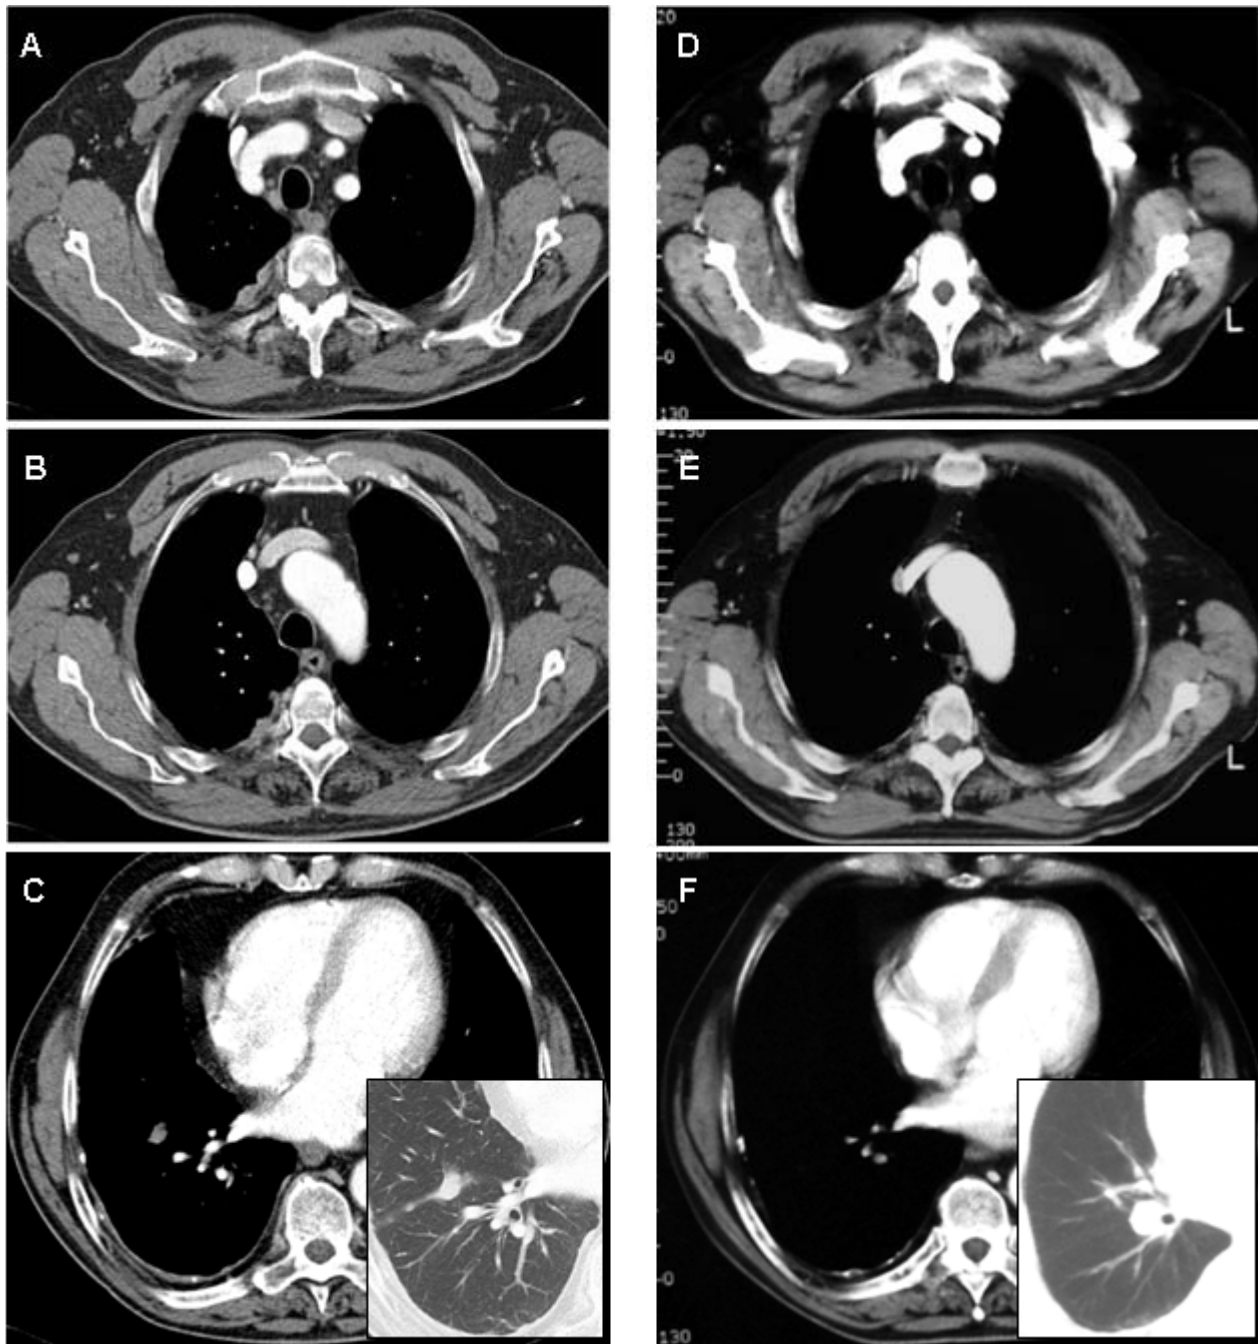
Mediastinal windows of CT-scan before chemotherapy showed right pleural thickenings and interlobar septal nodule-like feature (A-C); disease re-staging with CT-scan at the end of the four cycles of chemotherapy showed the disappearance of most of the lesions (D-F). The involvement of the lung fissure is more evident in the lung window (C, F).
